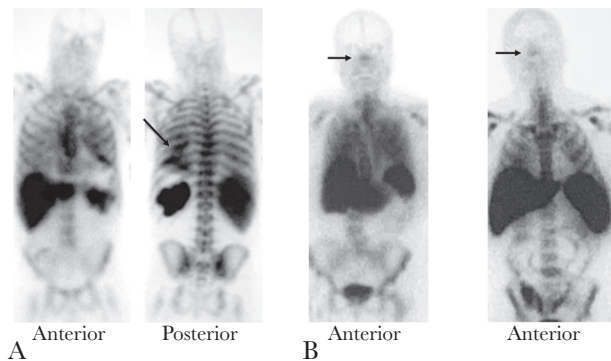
TP and FN, same patient. A, Tc-99m-WBCS shows LLL pneumonia (arrow, posterior view), but was already seen on previous CXR and 3 days later on CT. Sputum culture grew *Curvularia* the day before. Bronchoscopy 2 days later; washings grew a variety of mold and fungi. This led to CT sinus (patient uncommunicative) showing aggressive pan-sinusitis with bone erosion. Biopsy showed fungi and necrosis; patient was taken for surgical debridement. WBCS was FN for sinusitis. Slight prominence around orbits, nose, ethmoid sinuses is common on Tc-99m-WBCS, more so than on In-111-WBCS. B, For comparison, see examples of Tc-99m-WBCS in 2 other patients, both without sinusitis, anterior views only. Abbreviations: CT, computed tomography; CXR, chest x-ray; FN, false-negative; LLL, left lower lobe; TP, true-positive; WBCS, white blood cell scintigraphy.
